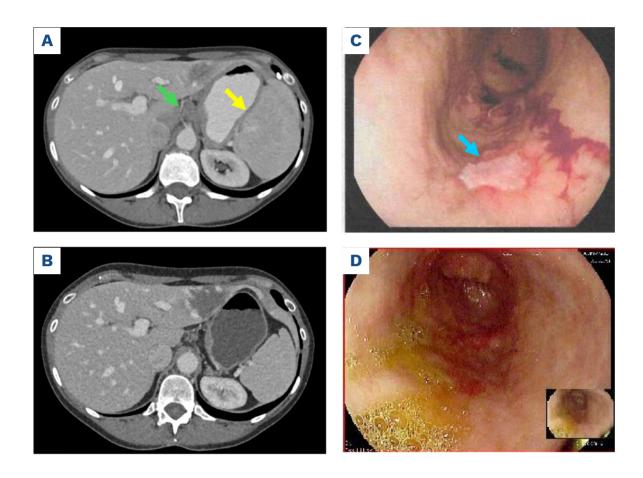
Computed tomography scan of the abdomen and gastroscopy before and after odronextamab therapy. (A) Computed tomography (CT) scan of abdomen with contrast medium performed before odronextamab therapy. The green arrow shows celiac tripod adenopaties. The yellow arrow shows moderate splenomegaly. (B) CT scan of abdomen with contrast medium performed after 3 months of odronextamab therapy showing regression of celiac tripod adenopaties and splenomegaly. (C) Gastroscopy performed before odronextamab therapy. The blue arrow shows a fibrinous ulcer. Gastric biopsy at this site showed clear involvement by marginal zone lymphoma. (D) Gastroscopy performed after 3 months odronextamab therapy showing a complete regression of the ulcer.
